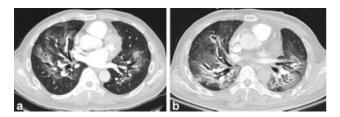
Radiation pneumonitis complicating radioembolization. A 56-year-old man with chronic hepatitis B and unresectable hepatocellular carcinoma in the right hepatic lobe with portal vein and inferior vena cava invasion was treated with hepatic radioembolization. Mapping angiography was completed, and the lung shunt fraction was estimated at 22%. He was treated with an estimated dose of 27 Gy. The patient developed dyspnea, and CT chest 4 months after treatment showed changes of "batwing" appearance of ground-glass attenuation with peripheral sparing (a). Despite treatment with steroids, symptoms were progressive on CT findings (b). The patient died shortly thereafter.
